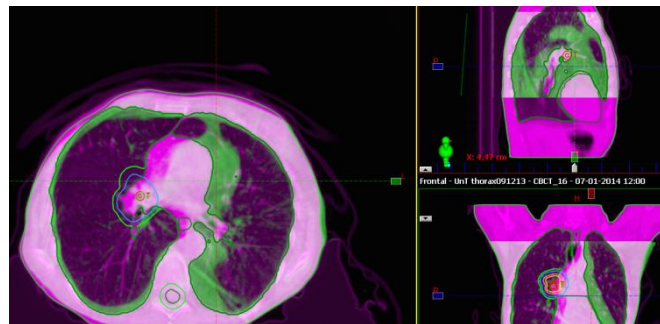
The bone registration of the CBCT at fraction 16 on the initial CT for patient 25 revealed a large anatomical change as a result of appearance of atelectasis to the right of the column which caused mediastinum displacement (green).
